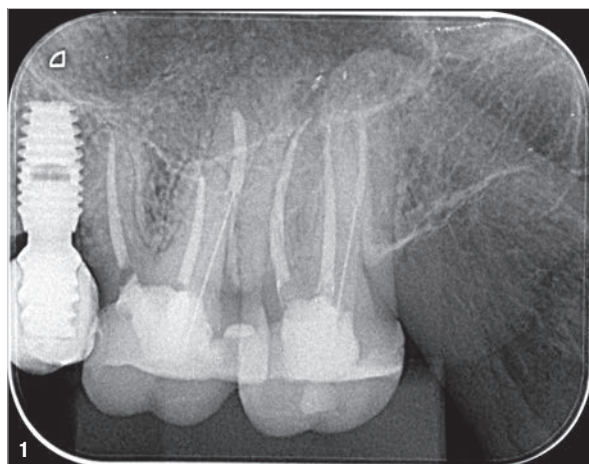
Radiographic view during first emergency consultation.
